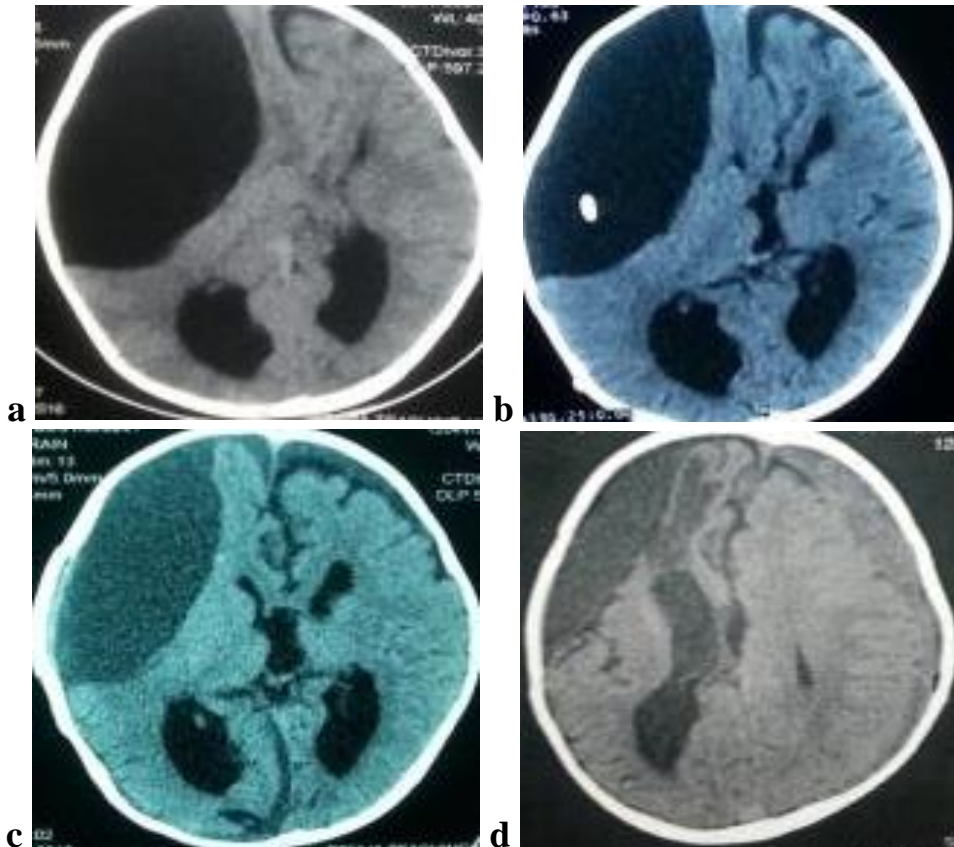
a-d): Radiological results of cystoperitoneal shunting and partial excision of large fronto-temporo-parietal IAC in 3 years old boy (CT brain axial images); a) pre shunting, b) 2 months post shunting with mild decrease in size and midline shift still present (complicated by shunt nephritis), c) 1 month post partial excision with fenestration shows opening of Rt ventricular horn and improved midline shift and d) 8 months post partial excision with more than 60% reduction of cyst size (measured intra-cystic pressure= 15 cm H₂O) and subdural hematoma was evacuated later.
